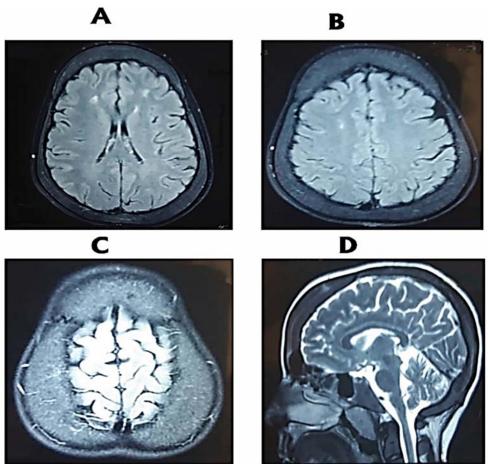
Brain magnetic resonance imaging (MRI) shows nonspecific subcortical white matter lesions. Note the significant widening of diploic space due to extramedullary hematopoiesis.
